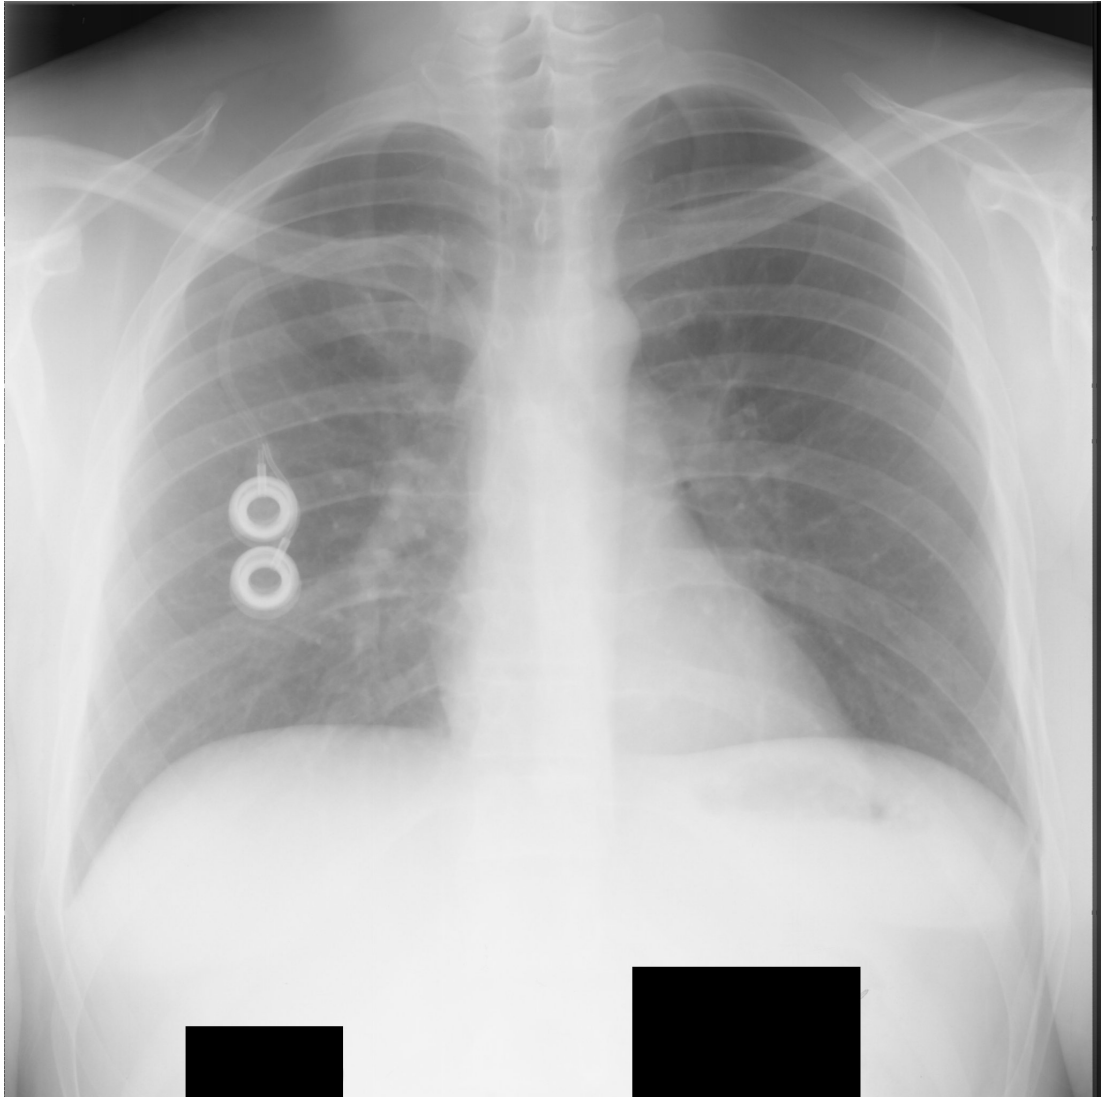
Another example for artificial object at the chest radiography. 5) Stapler. 6) Endotracheal tube. 7) Some electronic device. 8, 9, 10) Metal wires.
